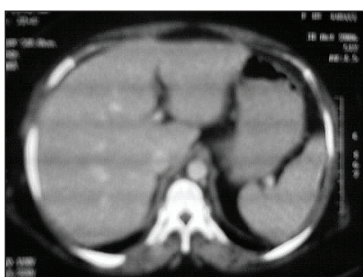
CT scan showing resolved ascites after treatment.
